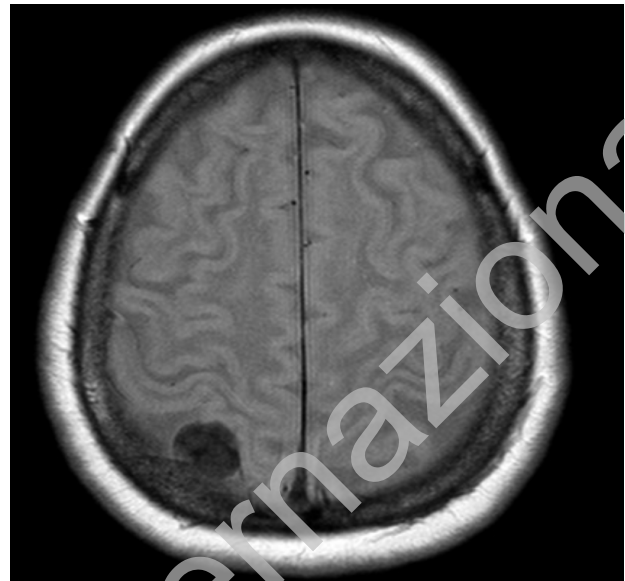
MRI axial view showing a mass in the convexity of right parietal lobe.
